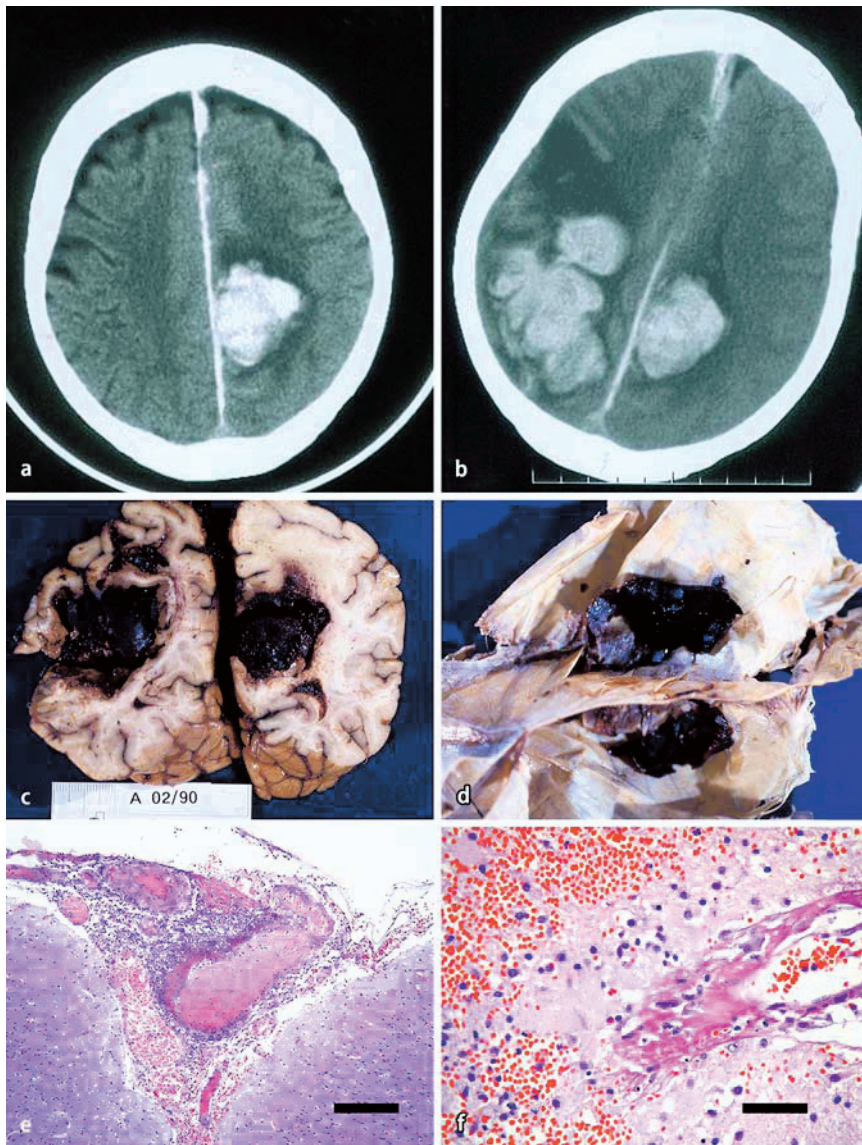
A Brain CT showing the first left frontal hemorrhage. B Brain CT showing the appearance of a second right frontal lobar hemorrhage with subdural extension four days after A. C, D The gross pathology of the brain shows the bilateral parenchymal hemorrhage and the subdural extension of the bleeding. E Microphotograph showing a corticomeningeal medium size arteriole with a transmural inflammatory process, the vessel wall is interrupted and destroyed by a mixed polymorphonuclear and mononuclear cell infiltrate (calibration bar: 200 μ m). F Higher magnification microphotograph of another small arteriole with segmental fibrinoid necrosis (calibration bar: 50 μ m)
